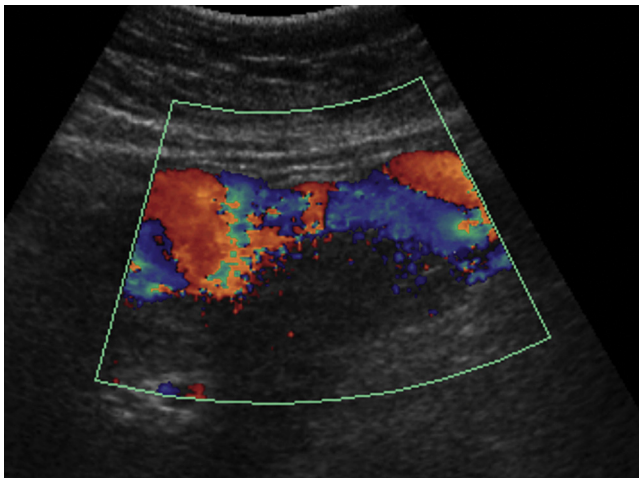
Varices from umbilical vein recanalization. The patient had a history of severe liver cirrhosis. There are dilated vessels just beneath the mid abdominal wall (along the course of umbilical vein) in this longitudinal sonography. The features are suggestive of umbilical vein recanalization with varices formation due to increased collateral flow. This figure is available in colour online at <http://carjonline.org/>.
